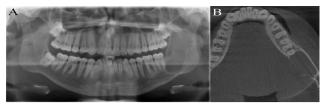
KCO. (A) PR showing a well-demarcated unilocular image. (B) CT allows the observation of buccolingual expansion and rupture of lingual cortical bone. PR, panoramic radiography.
